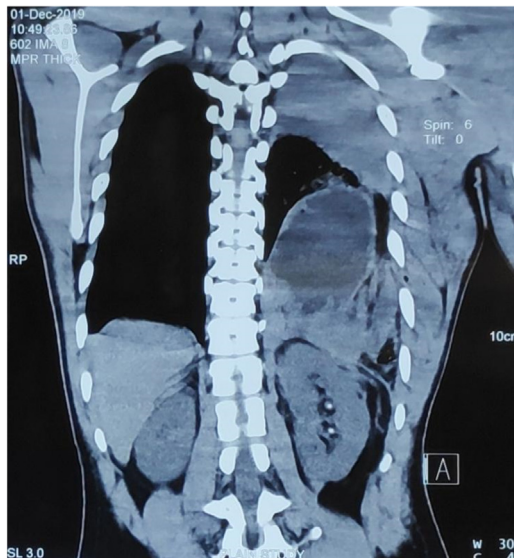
CT scan showing herniation of abdominal content into the left hemithorax.
